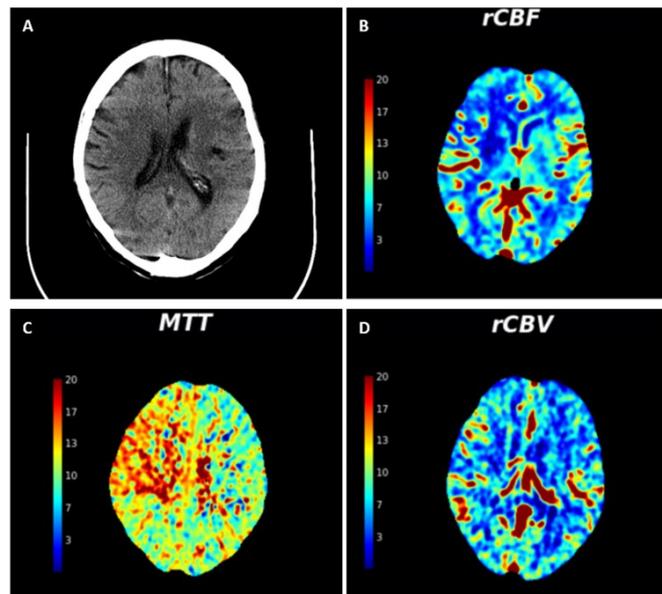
Perfusion source maps. A: Non-contrast CT Head, B: Cerebral Blood Flow map, C: Mean Transit Time map, D: Cerebral Blood Volume map.
